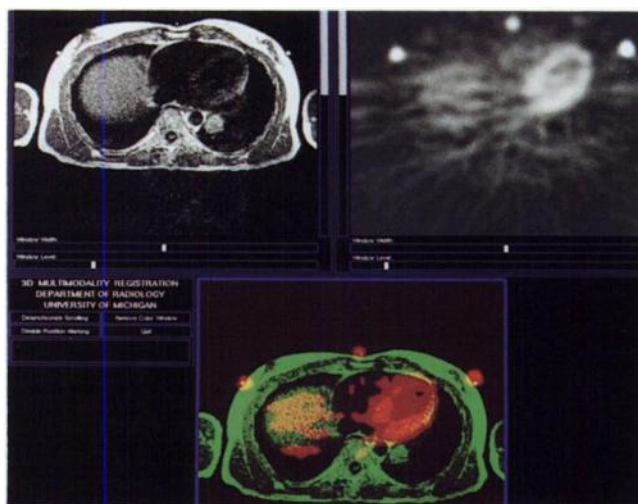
Patient with a history of germ cell carcinoma of the testis with multiple stable residual pulmonary nodules following aggressive chemotherapy. The upper left hand image is a T1-weighted (TR 667, TE 20) spin-echo MR image showing a retrocardiac nodule, a small nodule at the right costo-phrenic angle and three vitamin E markers positioned over the anterior chest. The FDG PET emission image at 60 min postinjection (upper right) clearly shows the three FDG fiducial markers at the same skin locations as the vitamin E markers, myocardial FDG uptake and a small photopenic area in the retrocardiac area. The fusion image (bottom) shows excellent registration between the FDG and vitamin E markers, demonstrates FDG uptake in the cardiac wall and shows no FDG uptake in either pulmonary nodule. Modest FDG uptake projects in the expected location for the liver. Follow-up of this patient showed stability of the pulmonary nodules most consistent with scarring and a lack of FDG accumulation.
